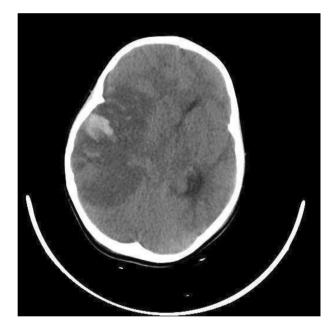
A brain CT scan of the patient on the fifth day of admission revealed necrotizing ischemic CVA and hemorrhagic transformation in the right MCA and PCA territory after post-COVID-19.
